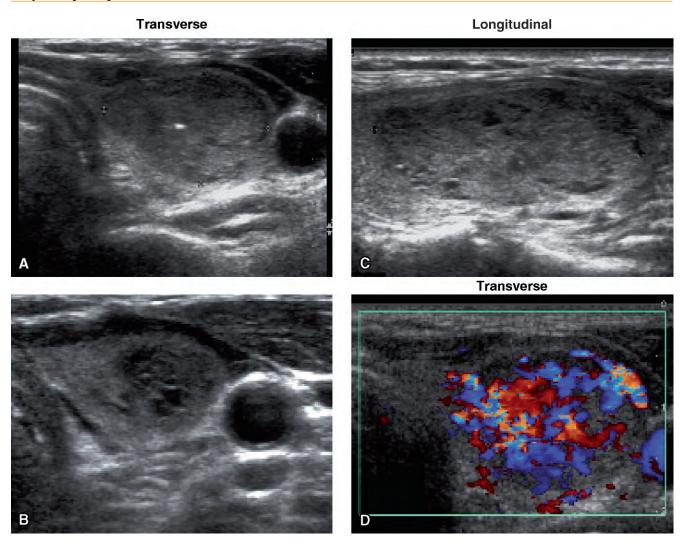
Ultrasound of papillary thyroid carcinoma in the left lobe. A and B, Transverse. C, Longitudinal. D, Color Doppler, transverse.
